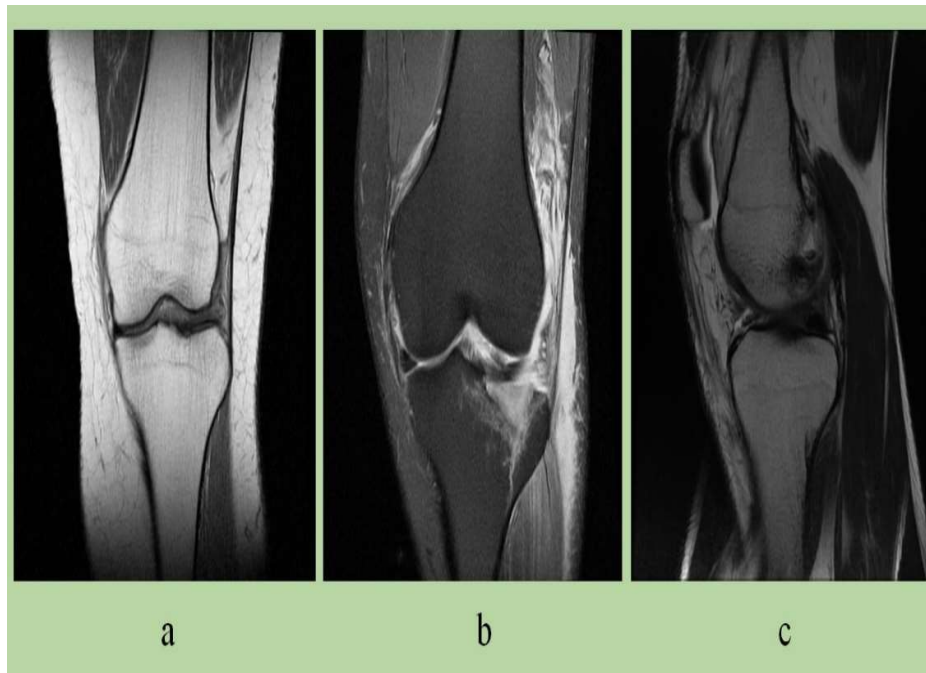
Knee MR image types (a) T1-weighted (b) T2-weighted (c) Flair
